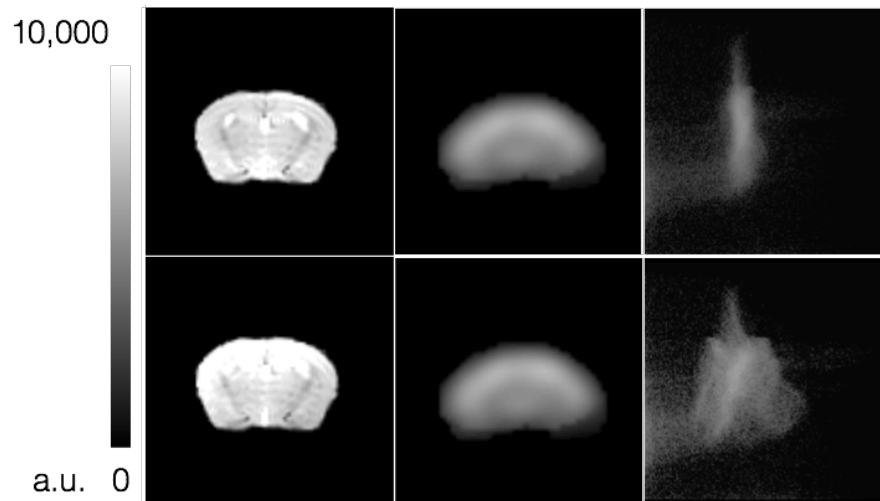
Effect of MR intensity inhomogeneity in the joint histogram. On the top row, the joint histogram of a manually registered PET-MR pair shows a compact cluster formed by a large number of intensity co-occurrences. On the bottom row, a less compact cluster is observed in the joint histogram when the MRI is affected with even low magnitude IIH.
